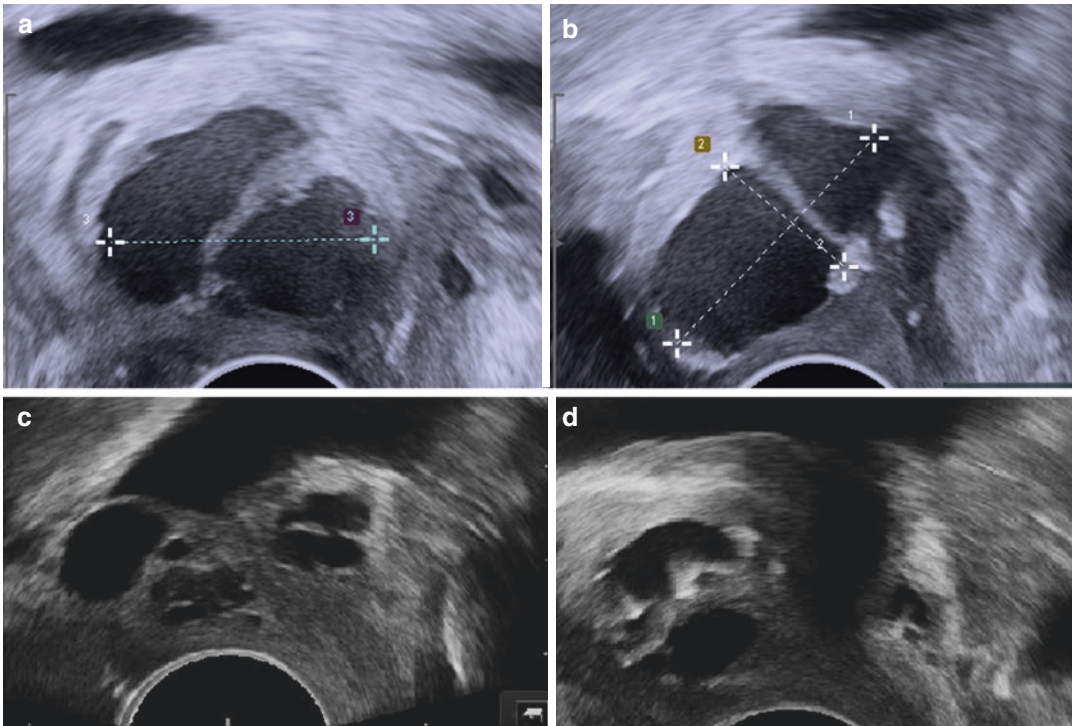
Complicated FUD using transvaginal in ultrasound. Large single diverticular with septum and dense content (qxil view) (a). Located in the proximal urethra with extension beneath the bladder neck (longitudinal
